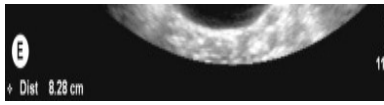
Ureteropelvic junction obstruction (UPJO): two cases. (Case 1) Newborn male child presenting with a large abdominal mass A: Abdominal radiograph showing abnormal displacement of the stomach and bowel to the right side of the abdomen. B: Portable ultrasound confirming the mass to be a large cystic lesion containing internal septations occupying most of the left side of the abdomen and pelvis but separate to urinary bladder. The right kidney was normal. A percutaneous drainage catheter was placed into the cyst draining urine. C: Appearances of the left kidney 1 week following decompression showing an echogenic dysplastic kidney. (Case 2) D, E: Longitudinal (D) and transverse (E) sonograms of a 1-year-old child with a severely hydronephrotic kidney with marked thinning of the renal parenchyma but no ureteric dilatation due to a UPJO. A MAG-3 isotope renogram confirmed poor drainage. A pyeloplasty procedure was subsequently performed.
